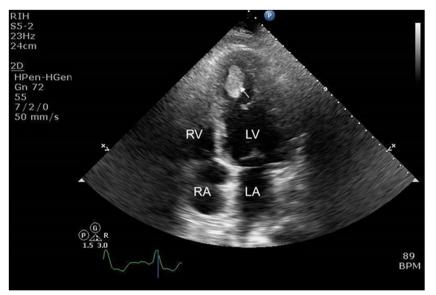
Transthoracic echocardiogram apical 4-chamber view in a patient with severely reduced left ventricular ejection fraction showing a large left ventricular apical thrombus (arrow). LA = left atrium, LV = left ventricle, RA = right atrium, RV = right ventricle.
